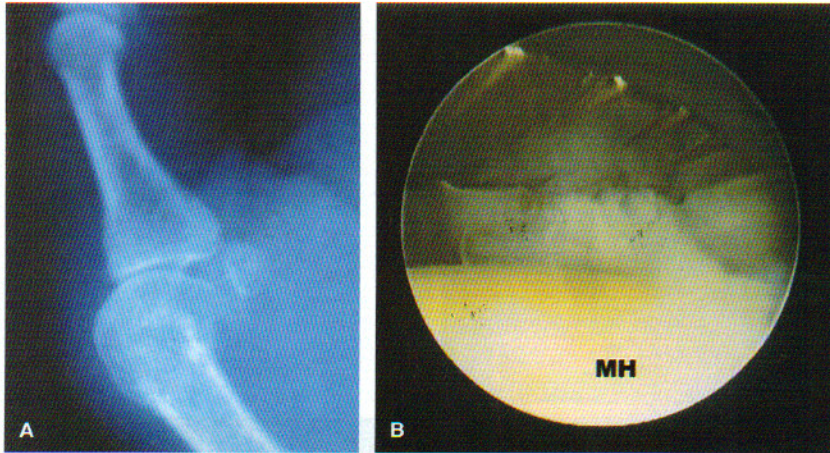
A. Lateral x-ray of the thumb, showing chronic volar subluxation of the MP joint of the thumb. Note the early degenerative changes. B. The volar plate being released with an Acuflex blade. It is critical that the release be done layer by layer with broad sweeping strokes to avoid deep puncture and possible digital nerve injury. Care must also be taken not to scuff the metacarpal head (MH).
